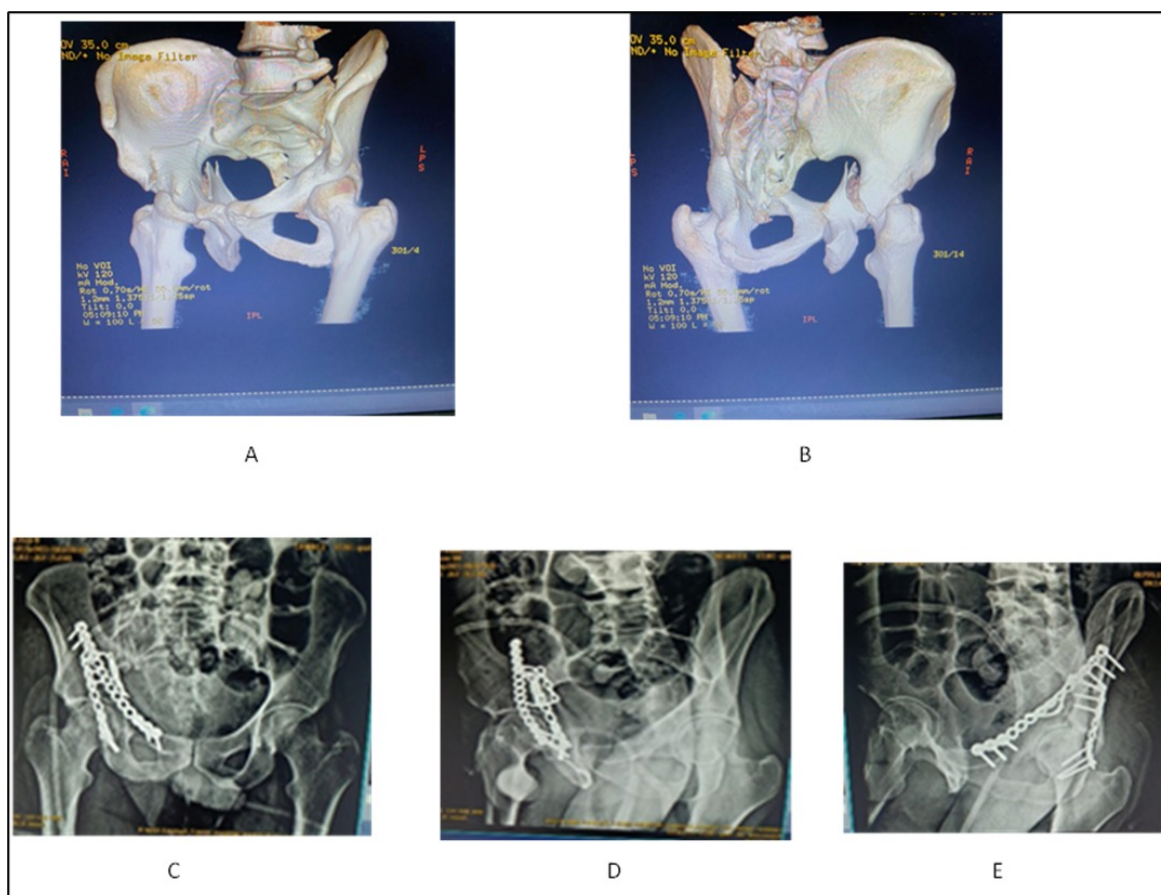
35 years old male patient, RTA, (A,B) preoperative CT scan showing transverse fracture acetabulum. (C,D,E) postoperative radiographs showing double column fixation through modified stoppa approach and Kocher langenebeck approach
